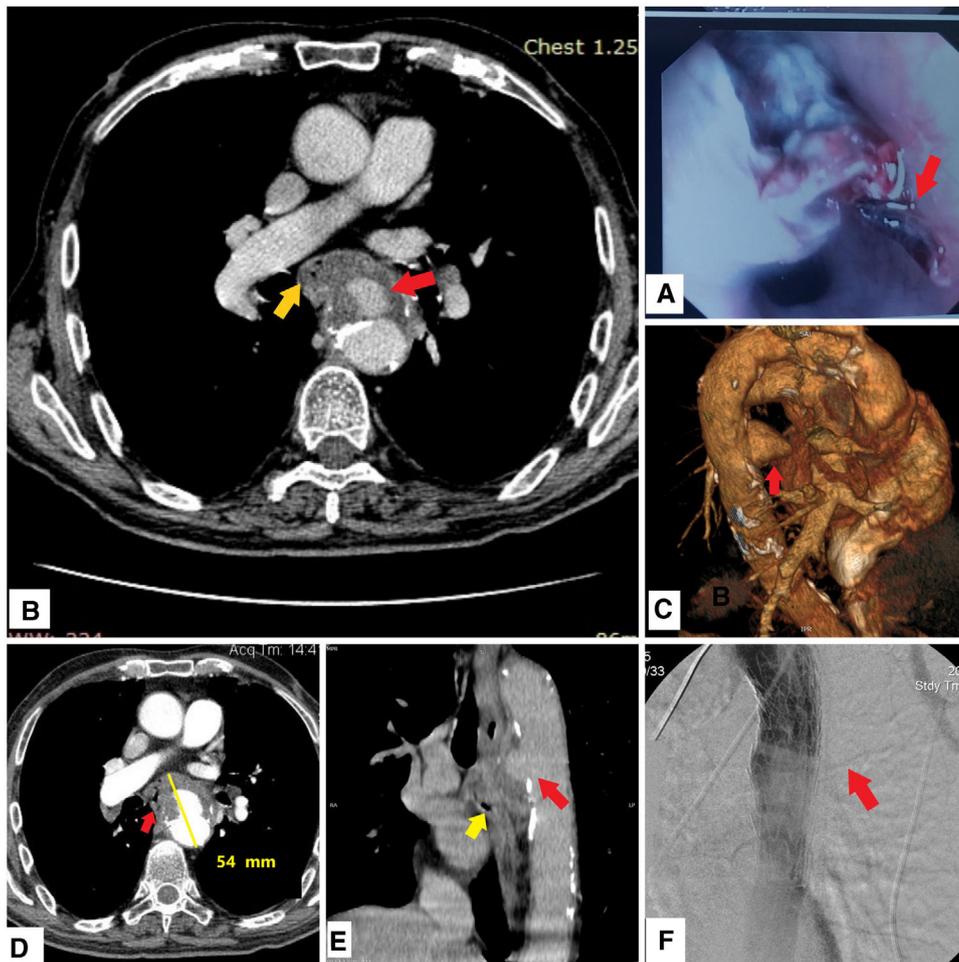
A. Endoscopy of the upper gastrointestinal tract, revealing the presence of blood clot at the proximal esophageal tract (red arrow) with erosion from a pulsative mass. B. Computed tomography angiography of aorta and thorax with intravenous contrast agent, axial view, depicting the presence of a sacular descending aortic aneurysm at the level of the tracheal carina, with mural thrombus (red arrow), and an aorto-esophageal fistula blocked by a part of the thrombus, protruding into the esophagus lumen (yellow arrow). C. Computed tomography angiography of aorta and thorax, three dimensional reconstruction, depicting the presence of the descending aortic aneurysm. D. Computed tomography angiography of aorta and thorax with intravenous contrast agent, axial view, depicting the presence of a sacular descending aortic aneurysm at the level of the tracheal carina with the presence of air within the thrombus's layers (red arrows). E. Computed tomography angiography of aorta and thorax with intravenous contrast agent, sagittal view, depicting the aneurysm's mural thrombus (red arrow), protruding into the esophagus lumen (yellow arrow). F. Invasive angiography, showing the result of the thoracic endovascular aortic repair procedure with coverage of the aneurysm with endovascular stent graft (red arrow).
